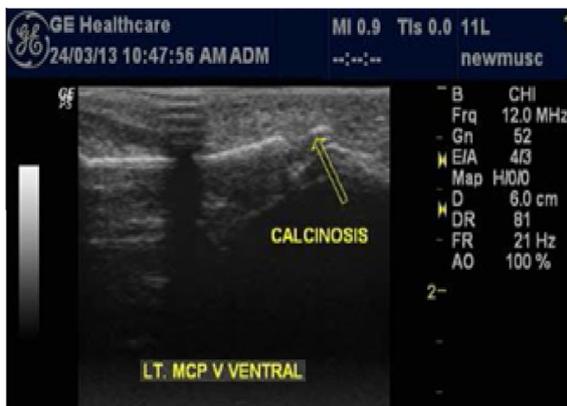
Ultrasonographic image showing intra-articular calcification within the MCP joint in a patient with RA (left) and in a patient with SSc (right).
